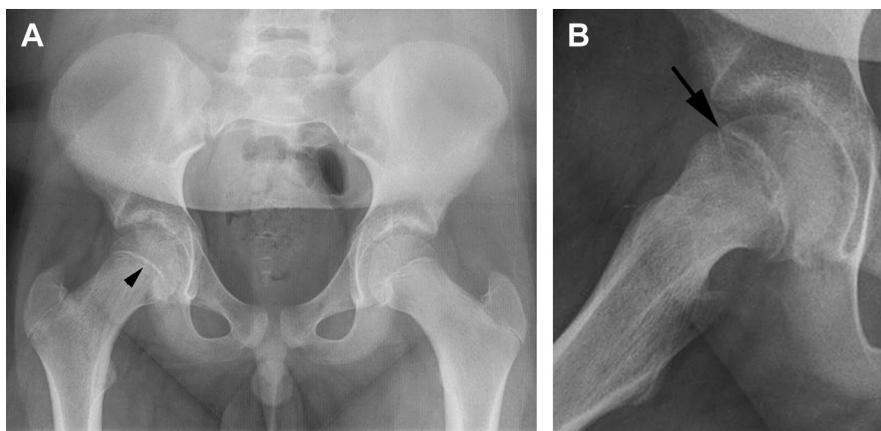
(A) A 13-year-old boy with right slipped capital femoral epiphysis. AP radiograph of the pelvis demonstrates widening and irregularity of the proximal right femoral physis (*arrowhead*). (B) A 13-year-old boy with right slipped capital femoral epiphysis. Frog leg lateral radiograph of the right hip demonstrates mild posteromedial displacement of the femoral head with respect to the neck (*arrow*).
